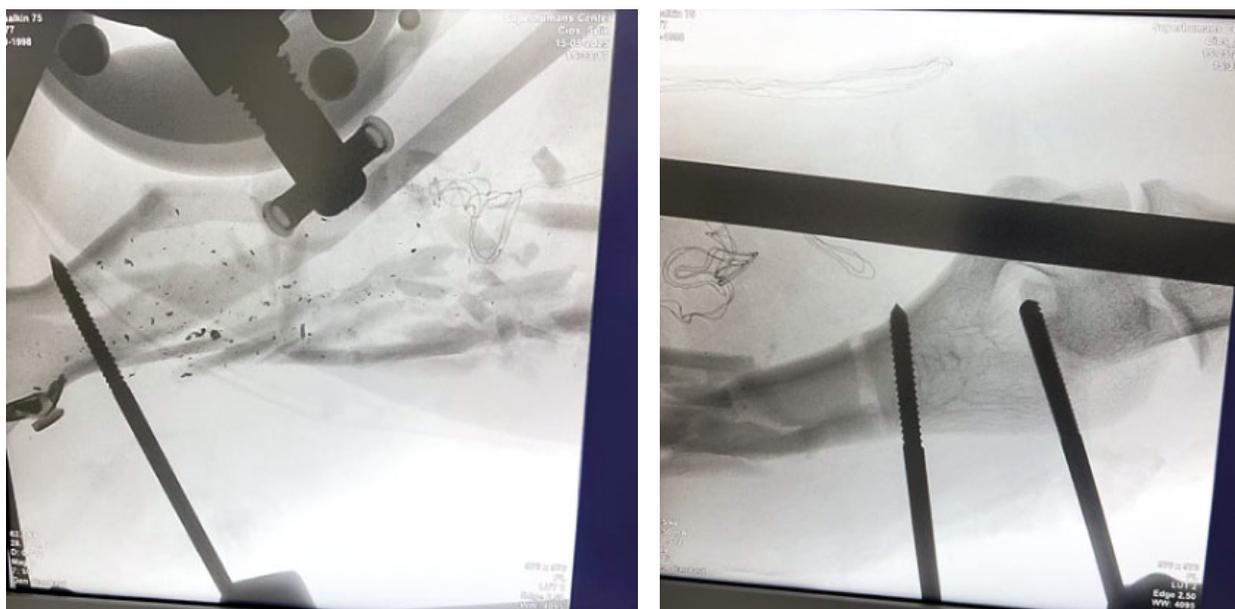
Primary intraoperative radiograph demonstrating a comminuted fracture resulting from a mine-blast injury and the pattern of damage requiring early orthoplastic planning after targeted evacuation to a specialized center
